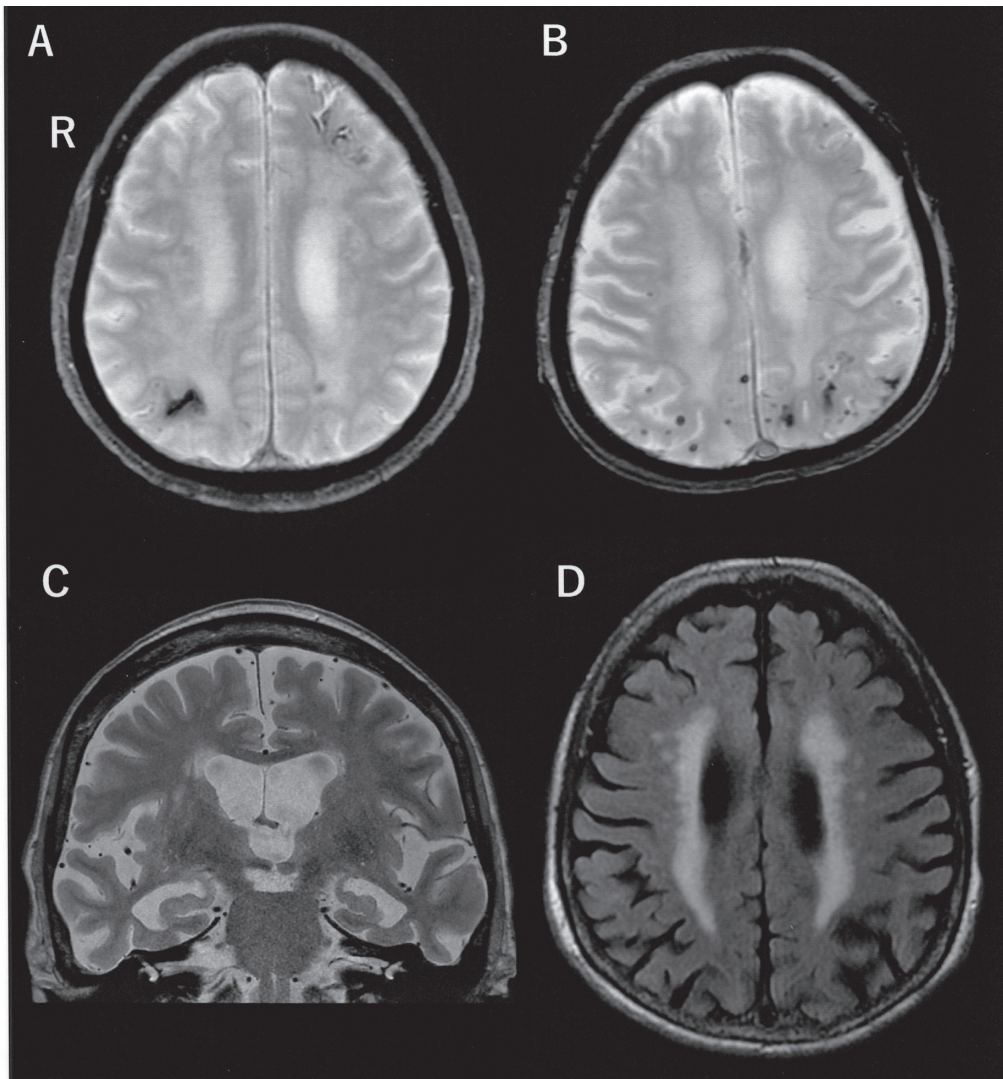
Representative magnetic resonance imaging (MRI) findings of patients with cortical superficial siderosis (cSS). A T2*-weighted image reveals cSS in the left frontal and right parietal lobes (A). Multiple cerebral microbleeds are evident in the bilateral parietal lobes on T2*-weighted images (B). Marked hippocampal atrophy is observed in a coronal section of a T2-weighted image (C). White matter lesions are observed on a fluid-attenuated inversion recovery (FLAIR) image (D). R, right. MRI, magnetic resonance imaging; and cSS, cortical superficial siderosis.
